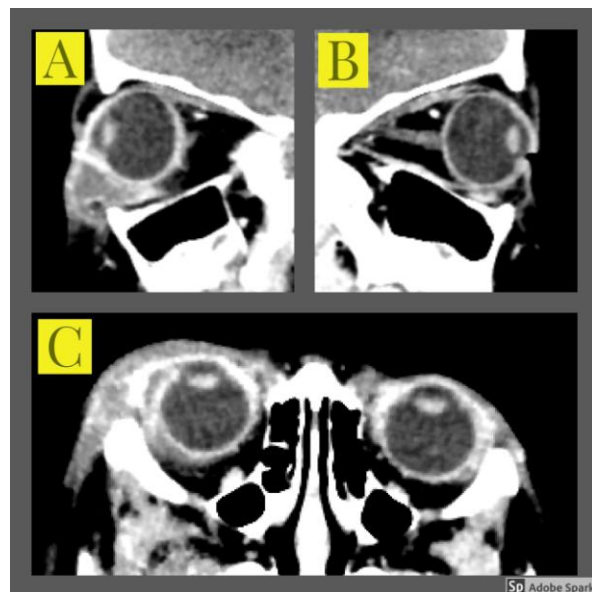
CT Orbit showing (A) a large abscess of the right lower lid, (B) minimal haematoma inferior to the left globe and (C) early signs of right orbital cellulitis.
